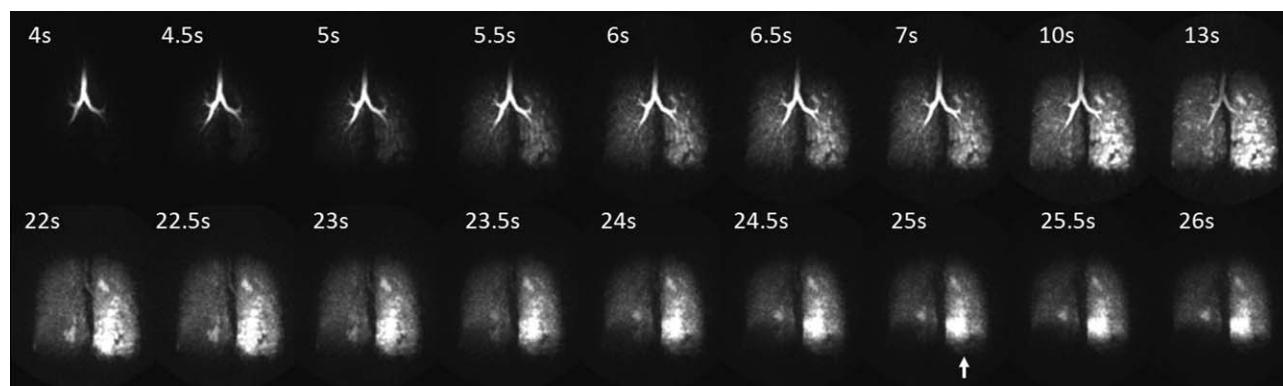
Coronal maximum intensity projections of a 3D dynamic imaging study using HP ^3He -MRI to assess ventilation and gas trapping using a forced exhalation maneuver in asthma. Breath-hold encompasses the time from 10–13 seconds followed by a forced exhalation maneuver showing gas trapping in the left lung most clearly visualized at 25 seconds (arrow). This patient's FEV₁ was normal, 94% predicted, before and after imaging suggesting significant subclinical heterogeneity and abnormalities of ventilation exist in this patient population.
